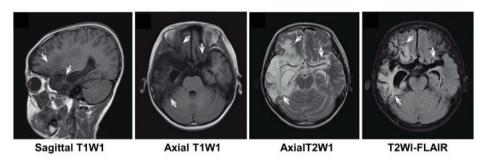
Magnetic resonance imaging detection of a representative pediatric patient (male, 13-year and 6-month old, admitted for convulsions for 1 week) with anti-N-methyl-D-aspartate receptor encephalitis. Multiple long T1 and long T2 signal shadows were noted in the bilateral frontal and temporal lobes, right thalamus and corpus callosum, which was obvious in the right front temporal lobe (as indicated by white arrows). Fluid-attenuated inversion recovery sequence mainly demonstrated high signals, within which low signals could be observed. Widened and deepened adjacent fissures were observed, as well as slightly enlarged bilateral lateral ventricle and third ventricle, with no obvious shift of the midline structure.
